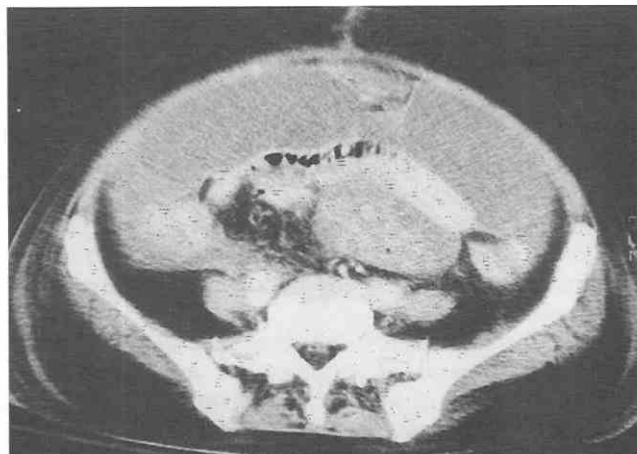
Perforated radiation enteritis in a patient with a history of radiation therapy for cervical cancer. CT scan shows bowel wall thickening of the ileum with a large amount of ascites and free gas (not shown).
